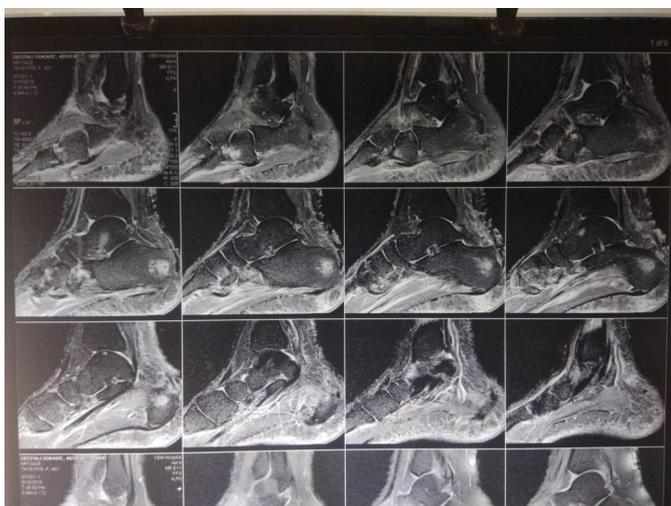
Postoperative MRI after two weeks.
